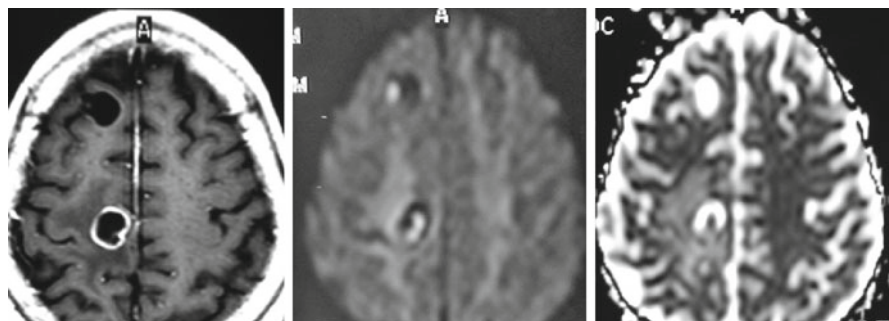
MRI of a patient with colloidal parenchymal brain cysticerci. Scolices are not visualized on contrast-enhancing imaging (*left*), but are well seen in diffusion-weighted images (*center*) and in the apparent diffusion coefficient map (*right*) (Reproduced with permission from: Del Brutto (2012b))
